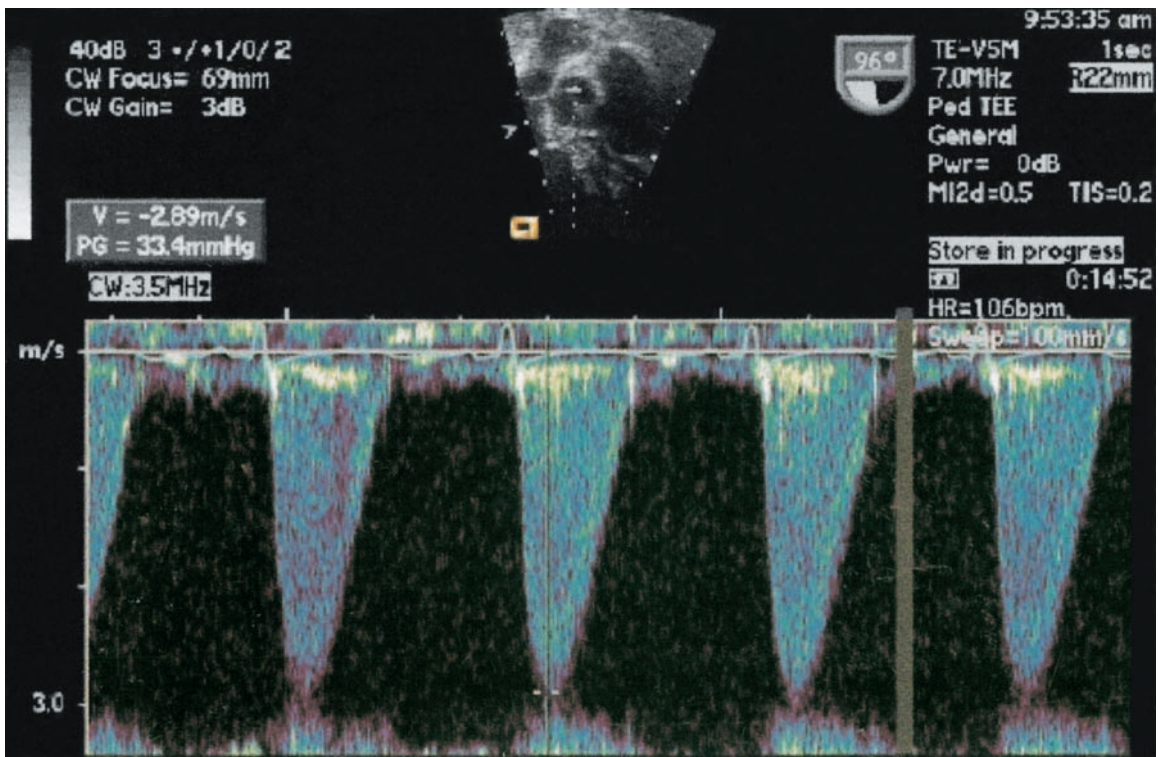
Continuous wave Doppler interrogation of left ventricular outflow tract in patient with subaortic obstruction demonstrating gradient estimation peak velocity across outflow measures 2.89 m/second, predicting a peak gradient of 33.4 mmHg (obtained by application of the modified Bernoulli equation or $4(V)^2$).
